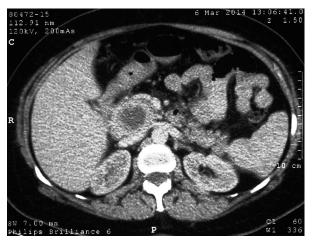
Computed tomography appearance of the duodenal gastrointestinal stromal tumor mistaken for cystic pancreatic neoplasm
